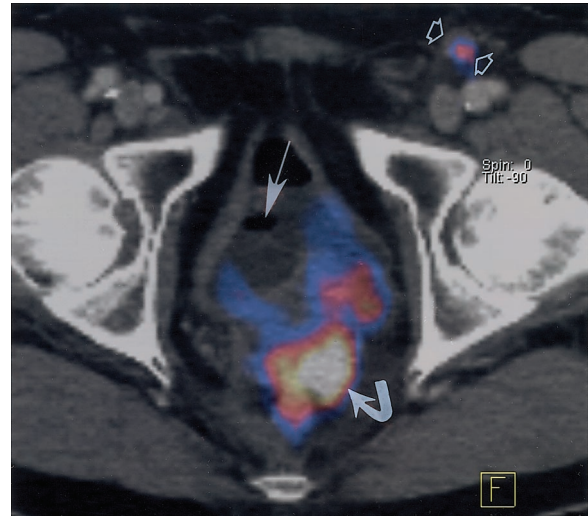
Recurrent colorectal carcinoma in a 65-year-old man after surgical resection. FDG PET-CT was performed to evaluate for recurrence. Axial fused FDG PET-CT image of the pelvis shows a Foley catheter in the urinary bladder (straight solid arrow). Recurrent disease in the pelvis (curved arrow) may be obscured by an FDG-distended bladder if catheterization is not used. Open arrows = metastatic left inguinal lymph node.
